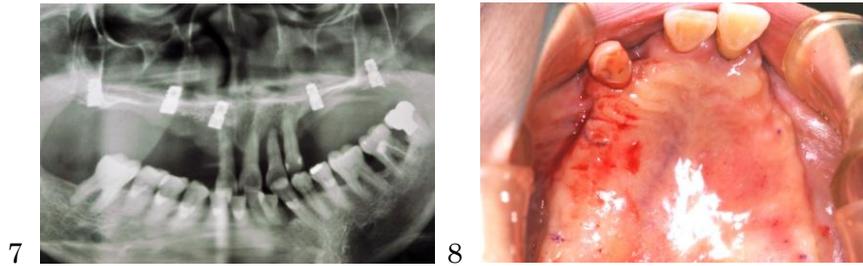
Postoperative radiograph. After GBR and the sinus-lift procedures, the two-piece type implant was sufficiently installed.
